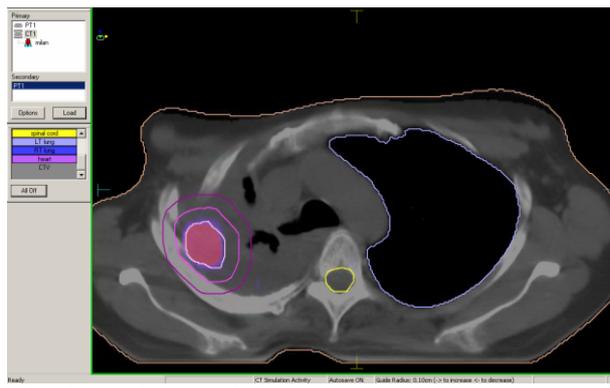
Positron emission tomography/computed tomography (PET/CT) findings (March 28, 2012) – the focus of intense ^{18}F -fluorodeoxyglucose (^{18}F FDG) accumulation in the projection described soft-tissue changes in the scar tissue of the lung top right.
